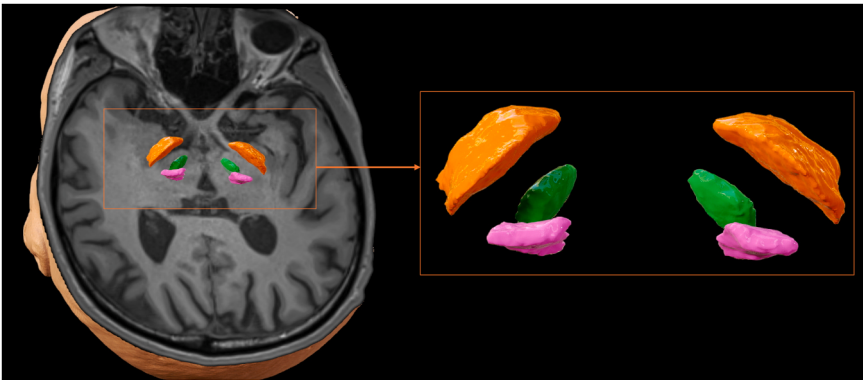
MR image showing three most common deep brain stimulation targets. The globus pallidus internus is highlighted in orange, the subthalamic nucleus is marked in green, and the ventral intermediate nucleus of the thalamus is depicted in pink.
